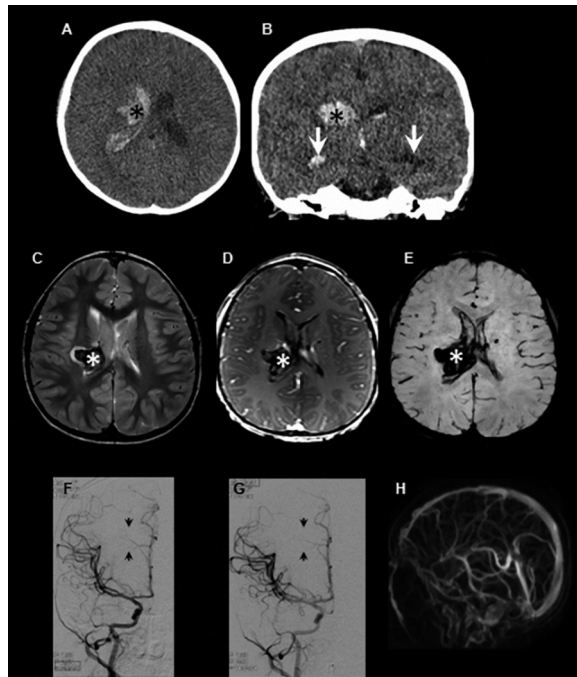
The initial noncontrast computed tomography (A-B) demonstrated that the intracerebral hemorrhage (*) extended into the lateral ventricles; note mild dilatation of the temporal horns (arrows). A 3.0T magnetic resonance imaging (C-E) further depicted the intraparenchymal hemorrhage (IPH) (*) on T2-weighted images (C), postcontrast T1-weighted images (D), and susceptibility-weighted images (E); there were no enhancing lesions on the postcontrast images. Catheter angiograms performed initially (F) and at 8 days (G) found no vascular lesions (both right internal injections, location of IPH is denoted between arrows). Magnetic resonance venography (H) was negative.
